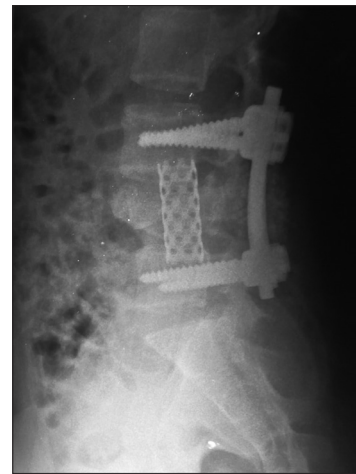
Postoperative lateral X-ray showing posterior fusion by rod and screws, anterior fusion by titanium mesh cage
